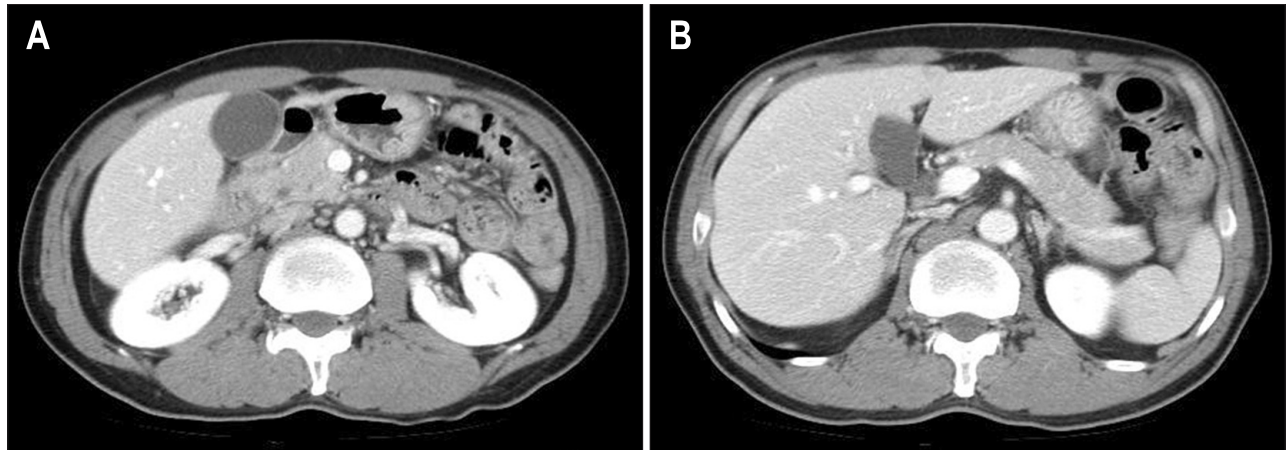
A 58-year-old Korean male presented to the emergency department of our institution with a 4-day history of lower abdominal pain with diarrhea and fever. He was diagnosed with infectious colitis. The results of an initial chemical profile were within the normal ranges. He received 400 mg of intravenous ciprofloxacin twice daily for 2 days while remaining nil per os for bowel rest. On the third day of treatment, he complained of severe abdominal pain. At this time, his serum amylase and lipase activities were elevated to 677 U/L (reference range, 45 to 160 IU/L) and 1,405 U/L (reference range, 42 to 168 mg/dL), respectively. (A, B) Abdominal computed tomography demonstrated swelling of the pancreatic head and peripancreatic inflammation. (A) Mild swelling of the duodenal second and third loops was noted. The patient was diagnosed with probable drug-induced pancreatitis secondary to ciprofloxacin using the Naranjo algorithm for assessing the probability of an adverse drug reaction.¹¹
